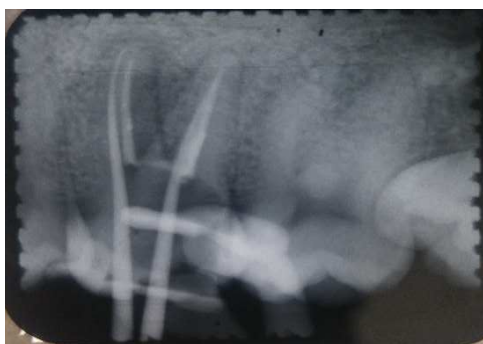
Radiographic confirmation of trial guttapercha
